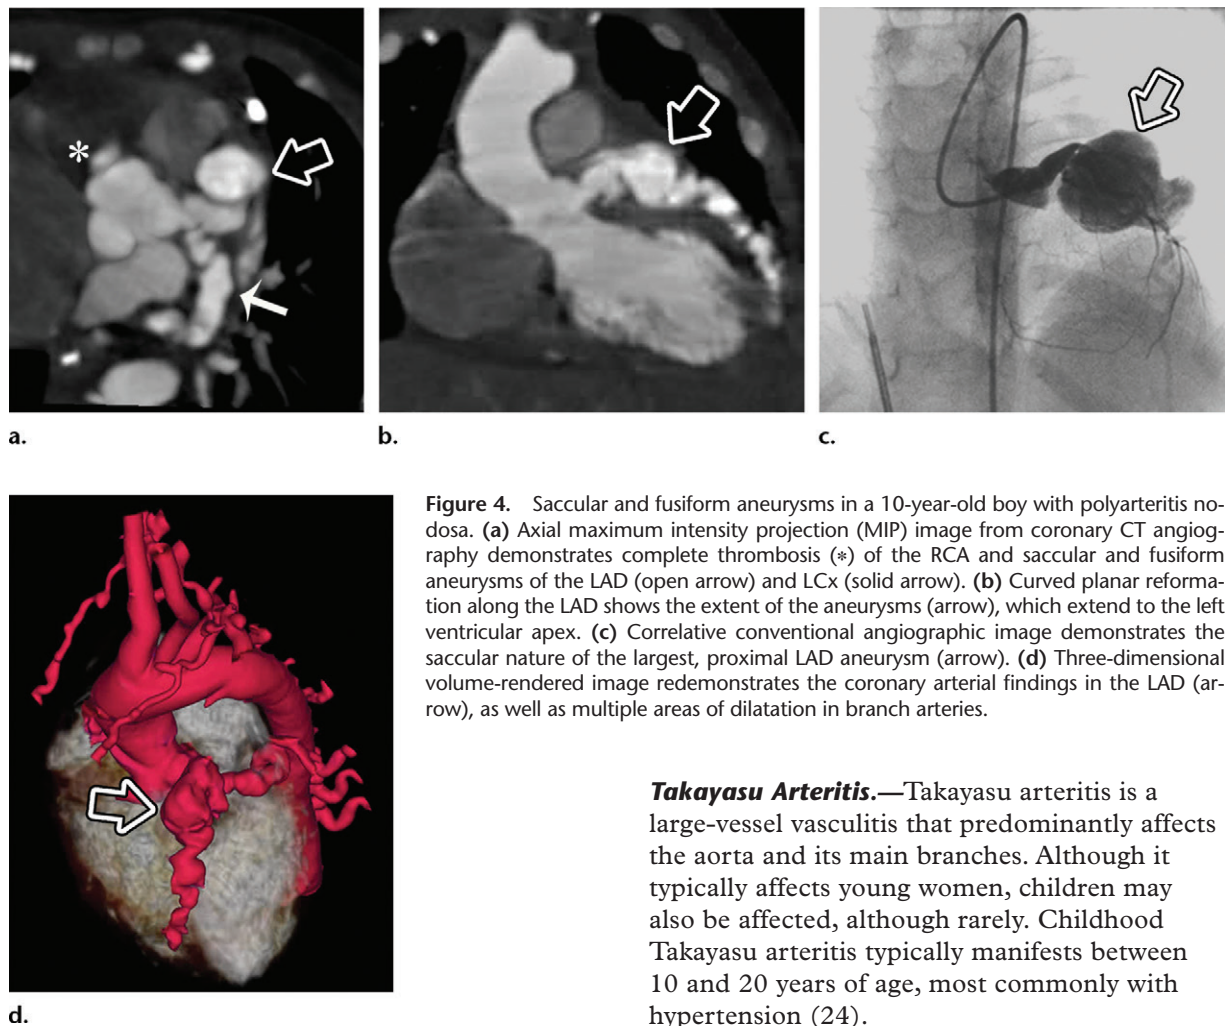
Saccular and fusiform aneurysms in a 10-year-old boy with polyarteritis nodosa. (a) Axial maximum intensity projection (MIP) image from coronary CT angiography demonstrates complete thrombosis (*) of the RCA and saccular and fusiform aneurysms of the LAD (open arrow) and LCx (solid arrow). (b) Curved planar reformation along the LAD shows the extent of the aneurysms (arrow), which extend to the left ventricular apex. (c) Correlative conventional angiographic image demonstrates the saccular nature of the largest, proximal LAD aneurysm (arrow). (d) Three-dimensional volume-rendered image redemonstrates the coronary arterial findings in the LAD (arrow), as well as multiple areas of dilatation in branch arteries.
